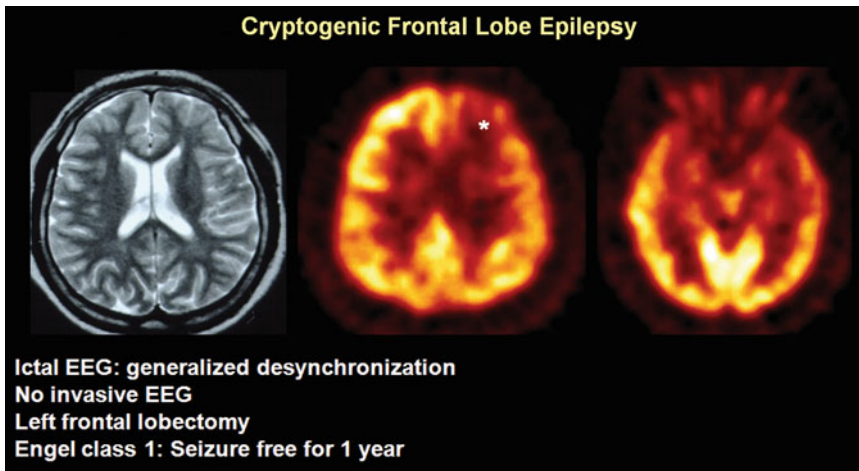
A case with cryptogenic frontal lobe epilepsy. Selected axial T2-weighted, MR image of the brain was normal, and ictal EEG also was nonlocalizing. Selected axial FDG PET showed images of the head, definitive
